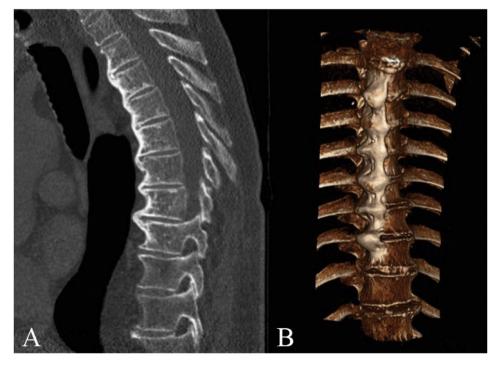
Computed tomography scan of a 70-year-old male patient. In A, the sagittal reconstruction is shown, clearly demonstrating bridges of bone over more than four vertebral bodies. In B, the three-dimensional reconstruction demonstrates the flowing cortical new bone.
